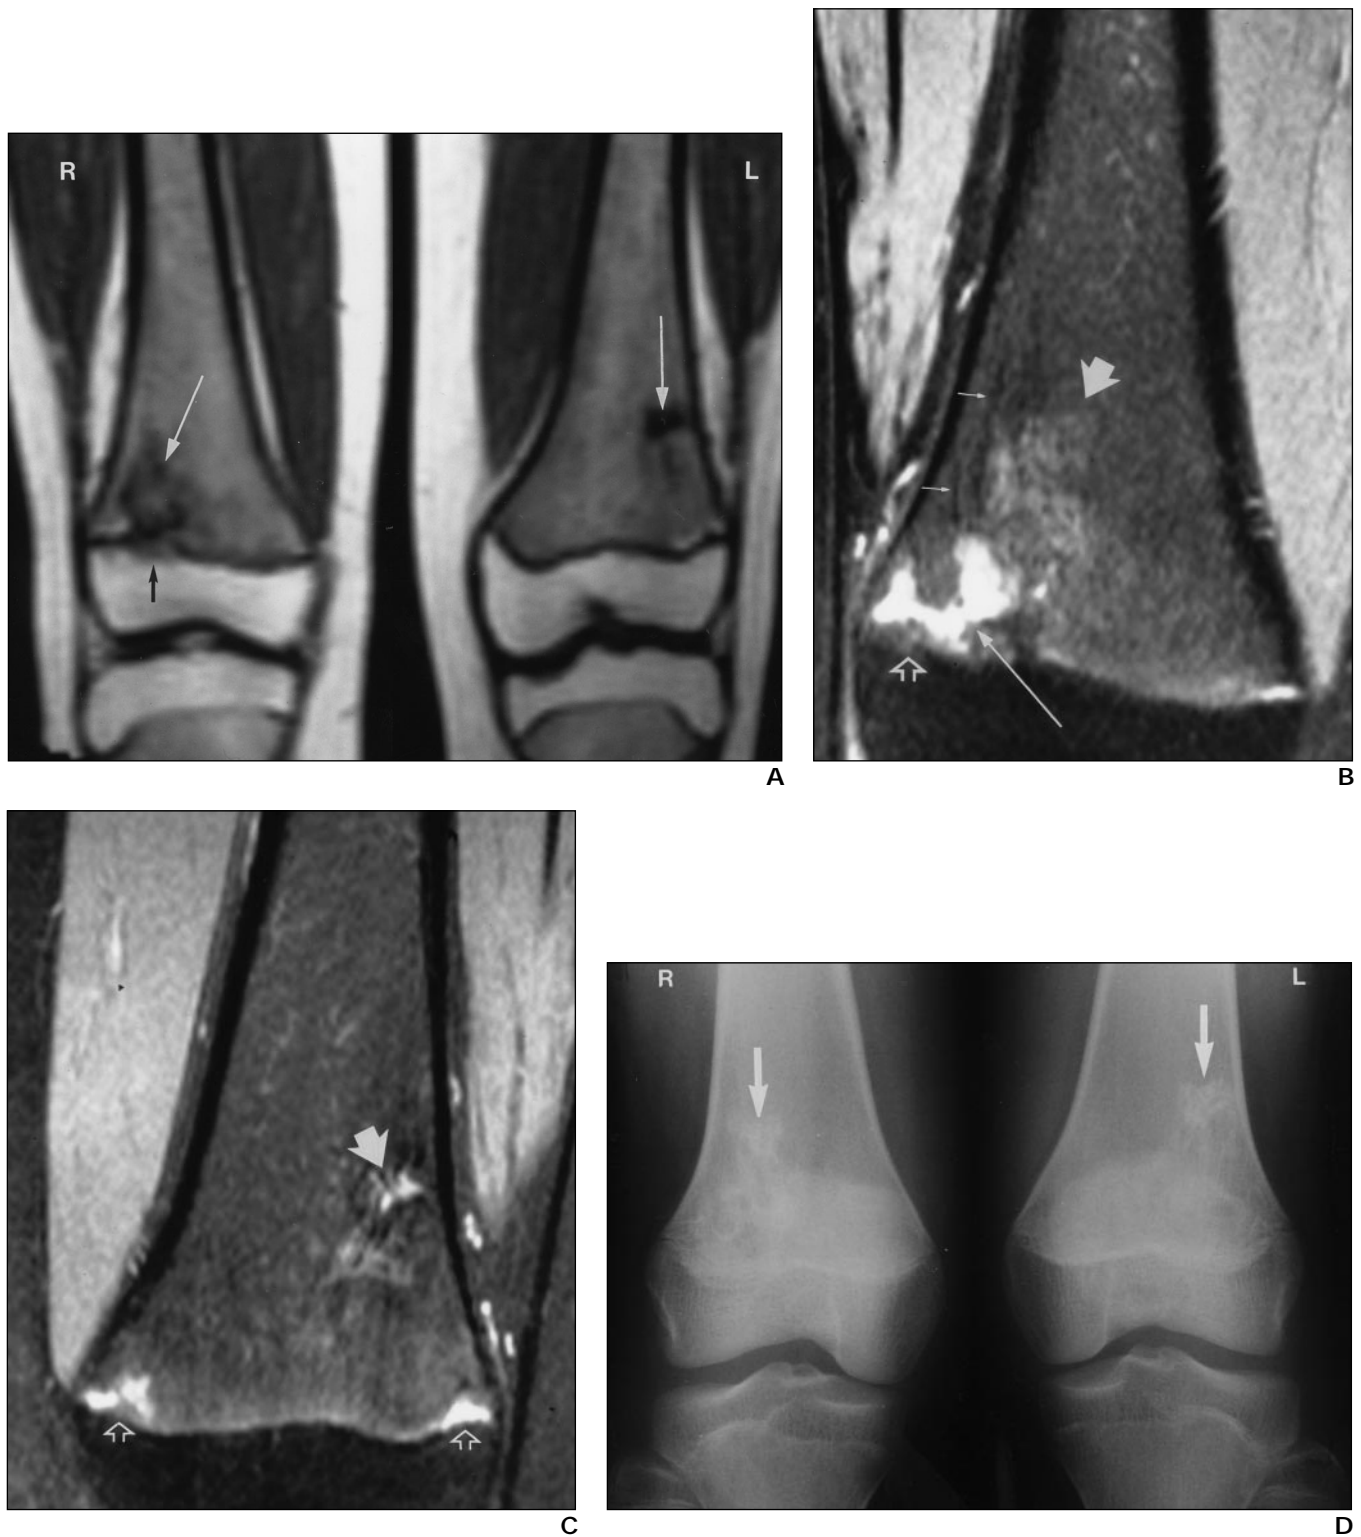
16-year-old girl who underwent chelation therapy for 9 years. Her height was at third percentile at time of MR imaging.
